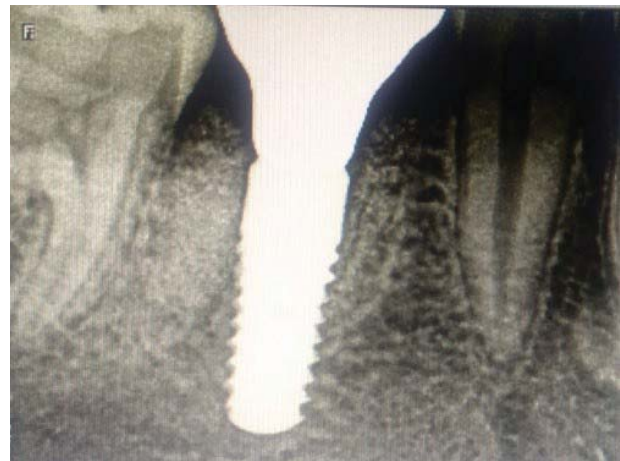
Radiograph after placement of Implant crown
